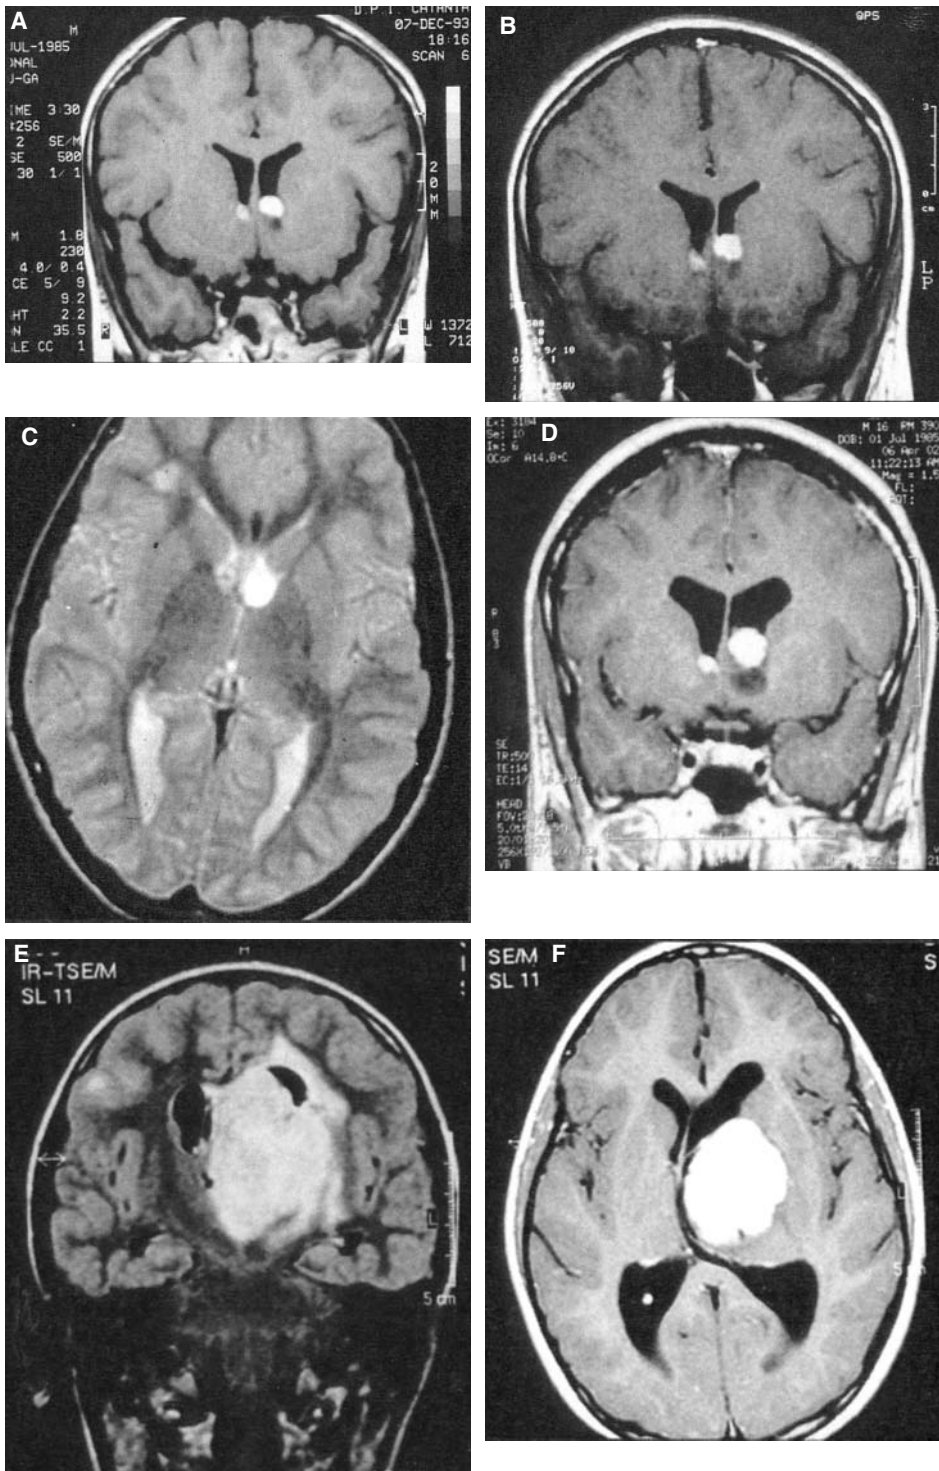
(A–G) Natural history of a growing subependymal nodule transforming into a giant cell tumour. Coronal T1-weighted (A, B, D, E), axial T2-weighted (C) and T1-weighted (F) and sagittal T1-weighted (G) magnetic resonance images of the brain show the progression of one subependymal nodule (located near the left foramen of Monro: right aspect of the figures) which starts as a “larger” subependymal nodule with a minor cystic component in the lower aspect of the lesion (A, B) and grows up (C, D) to displace the surrounding tissues with cystic lesions within the mass (E–G).
